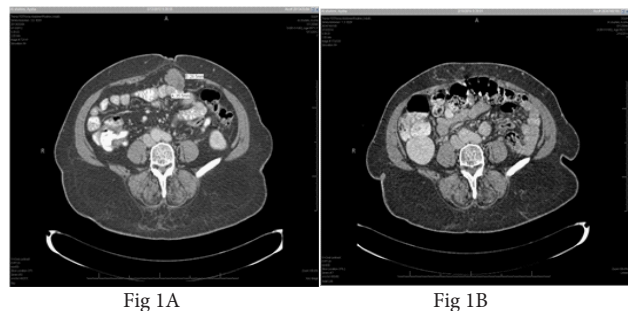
CT scan at the time of the 3rd relapse (Figure 1A) shows a 35 mm x 28 mm mass in the region of omentum, which disappeared completely after 6 cycles of carboplatin AUC 4 (Figure 1B).
